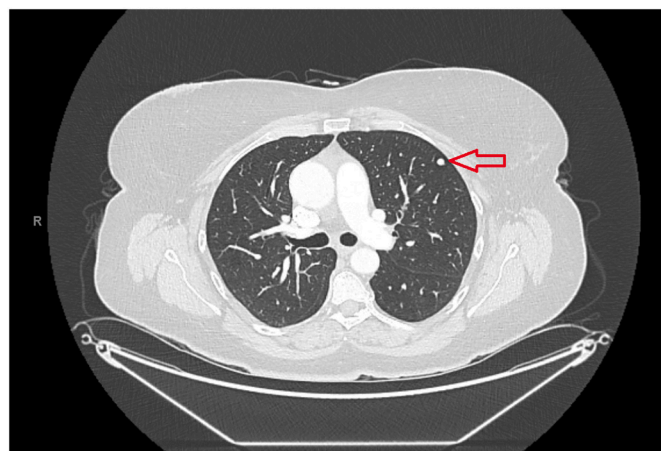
CT scan showing well-circumscribed millimeter nodular lung lesion of the left antero-superior pulmonary lobe.
